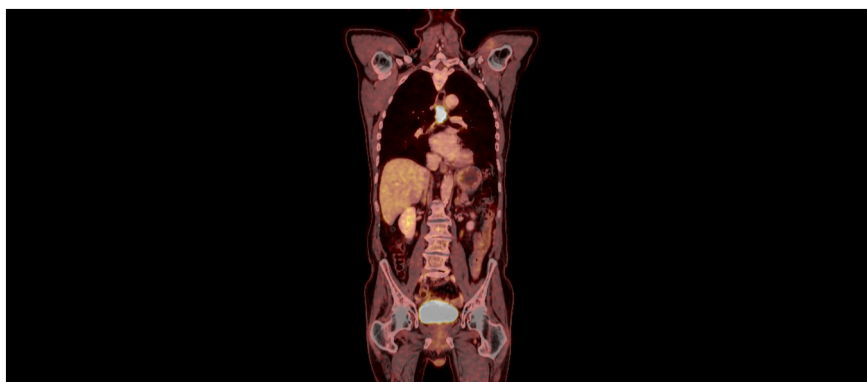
PET/CT - carcinoma of the middle oesophagus.
